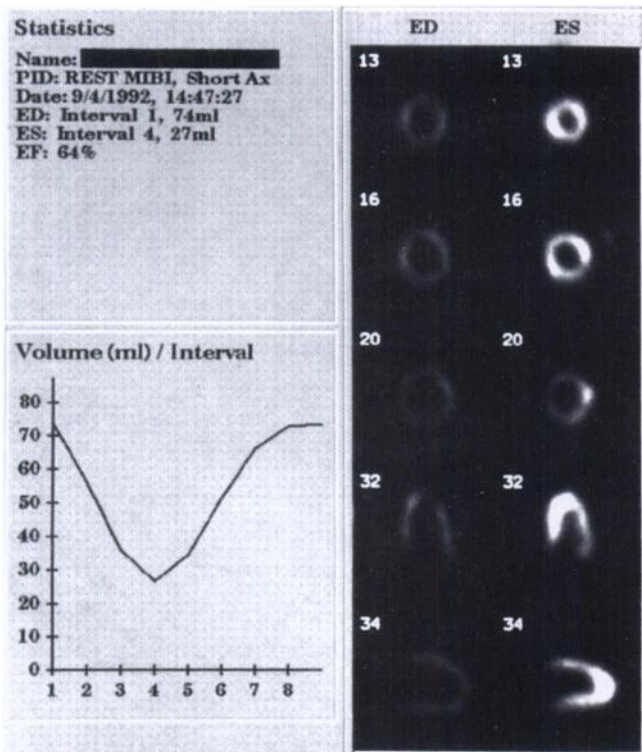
Quantitative gated SPECT algorithm results for the patient in Figures 5 and 6. The endocardial time-volume curve is displayed and the global LVEF (64%) is calculated and reported along with patient data and representative short- and long-axis images at end-diastole and end-systole.
